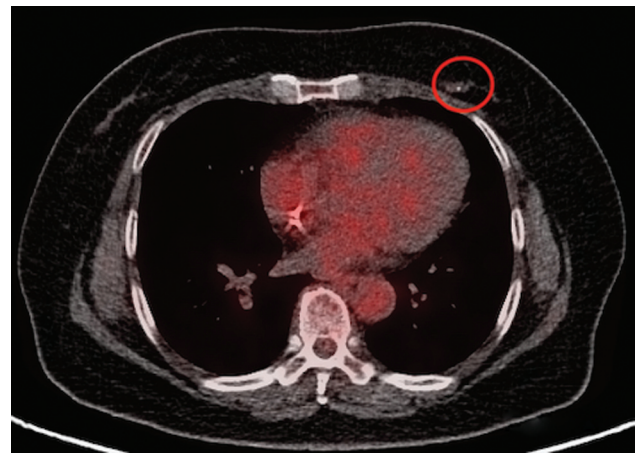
Post-chemotherapy ^{18}F -fluorodeoxyglucose positron emission tomography-computed tomography study demonstrates the posteromedial left breast mass with a biopsy clip (red circle) and without any fluorodeoxyglucose uptake.
